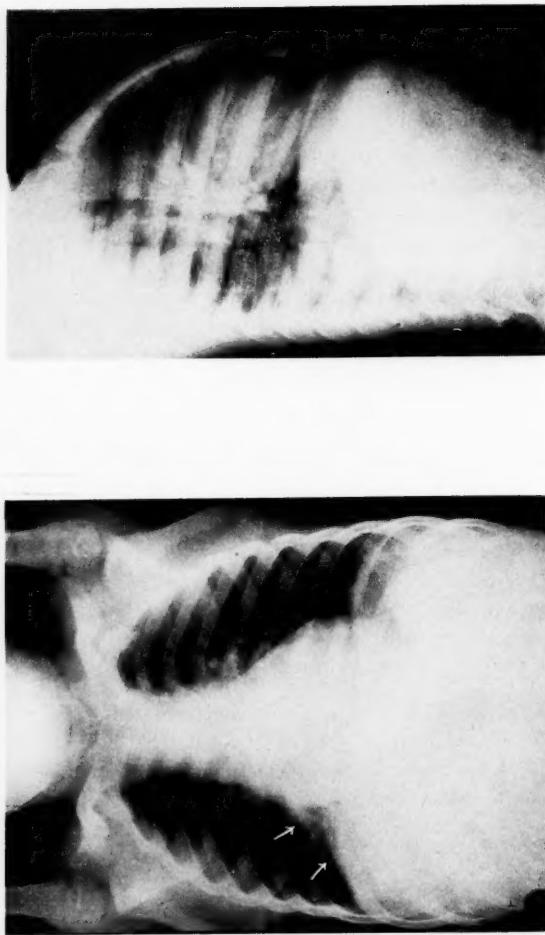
Radiographs showing early triangular shadow at the right base which persisted two months following an "atypical pneumonia." The child had a cough and a low-grade temperature, with physical findings of dullness and bronchial breathing at the right base.
